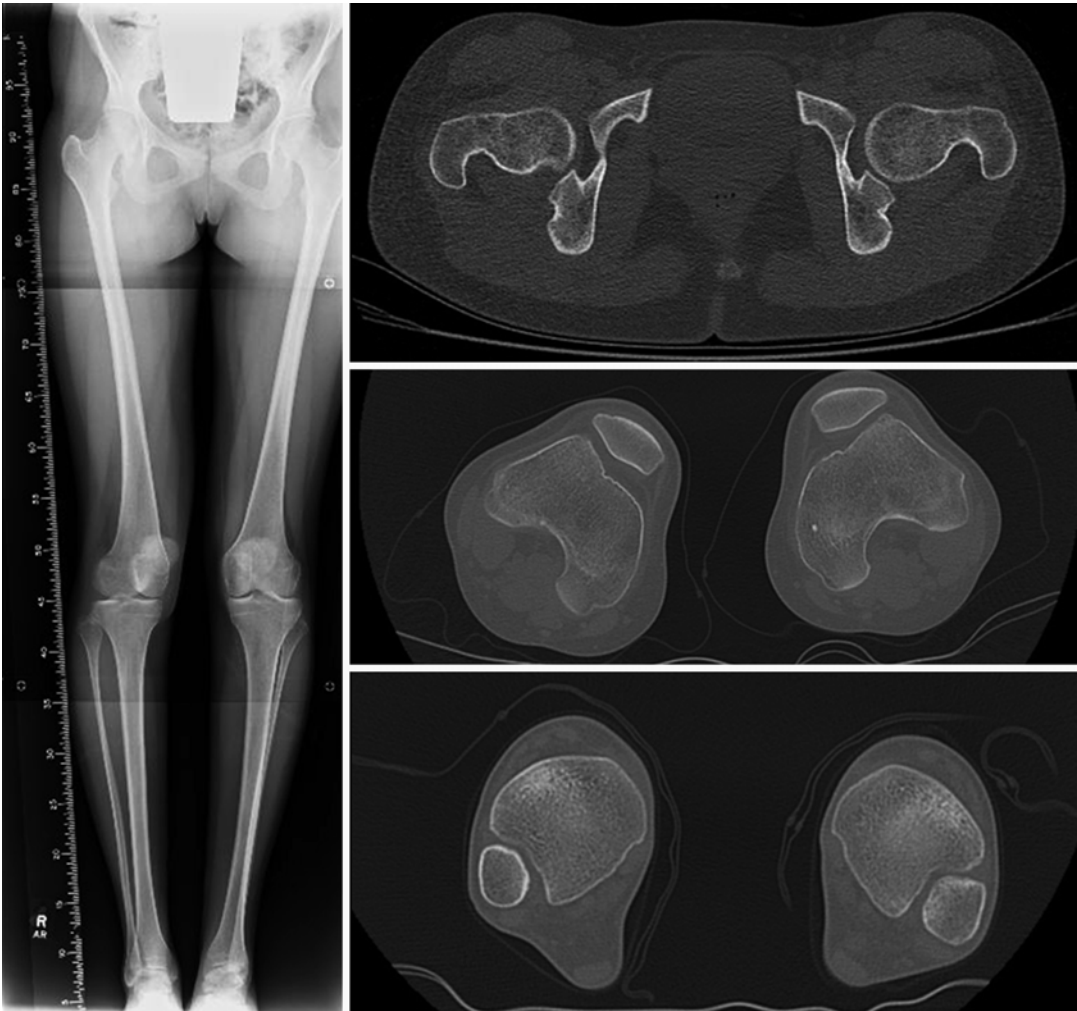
Radiological evaluation of torsion with CT scans
